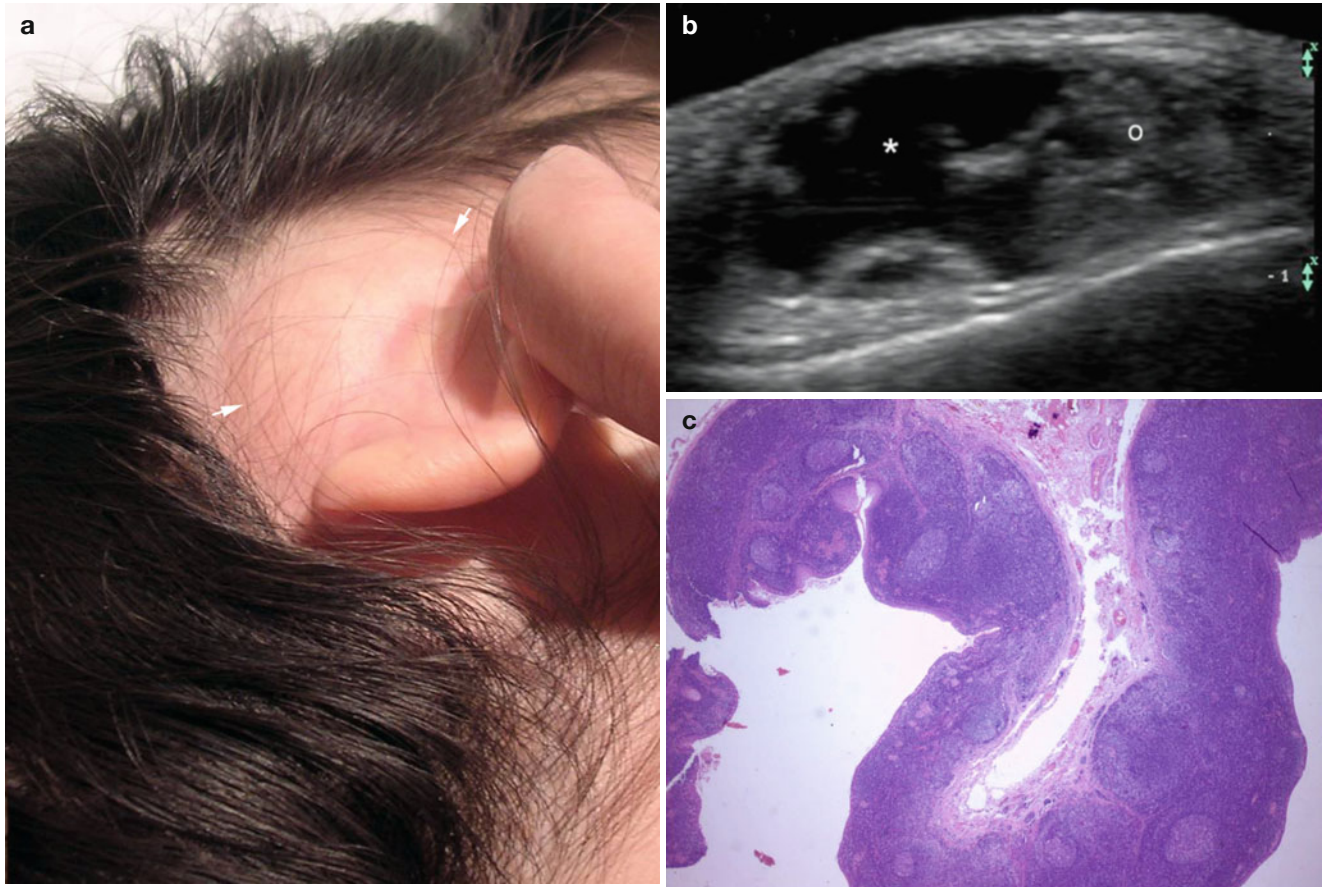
(a–c) Branchial cyst. (a) Clinical image shows a lump (arrows) in the right retroauricular region. (b) Ultrasound image (gray scale, longitudinal view) demonstrates large anechoic cystic structure (*, arrows) with thick hypoechoic walls (o) located in the subcutaneous
